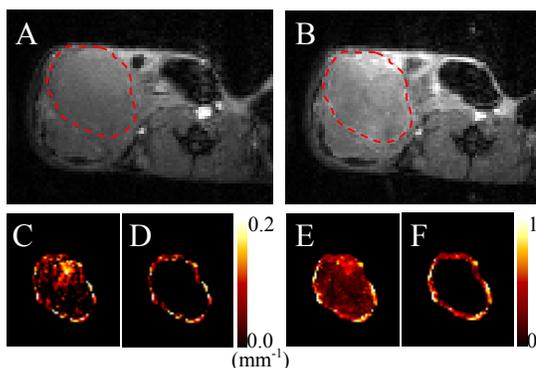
Representative DCE-MR images at (A) 1 minute before and (B) 2 minutes after gadoteridol injection with (C,D) K^{trans} and (E,F) v_e maps of the (C,E) entire tumor regions or (D,F) 0.5-mm thick peripheral tumor regions.
